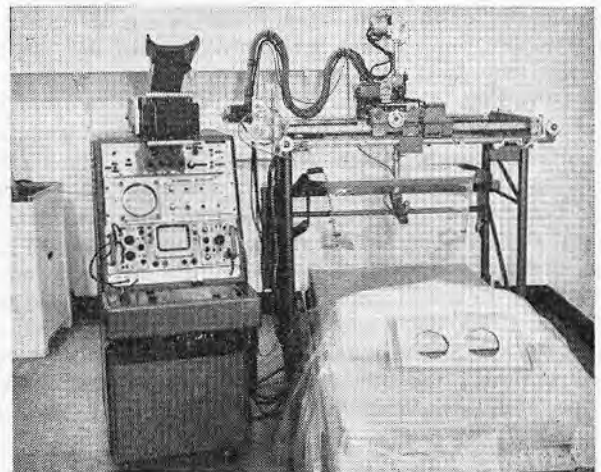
Ultrasonic echoscope.
